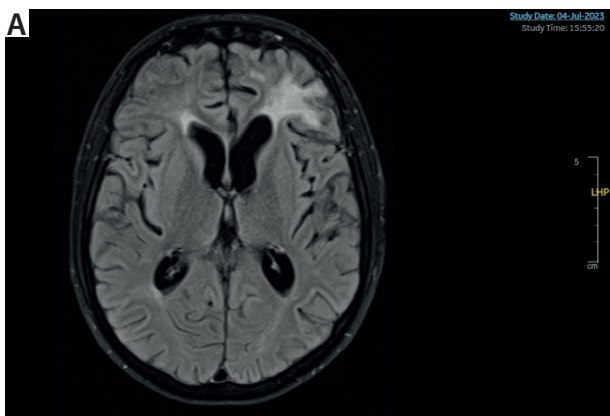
Magnetic resonance imaging after 2 months of hospitalisation
